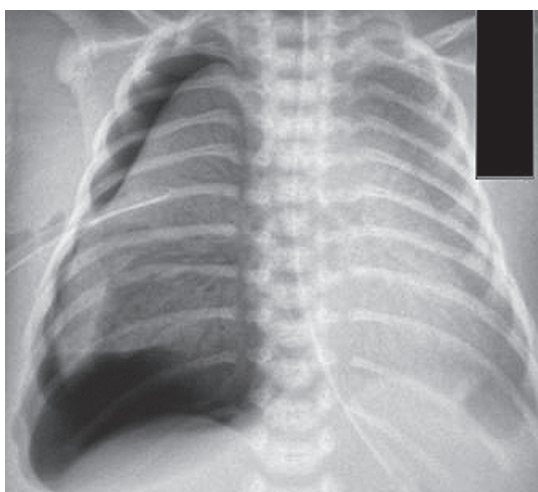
Chest X-Ray of newborn after monobronchial administration of proractant alpha
